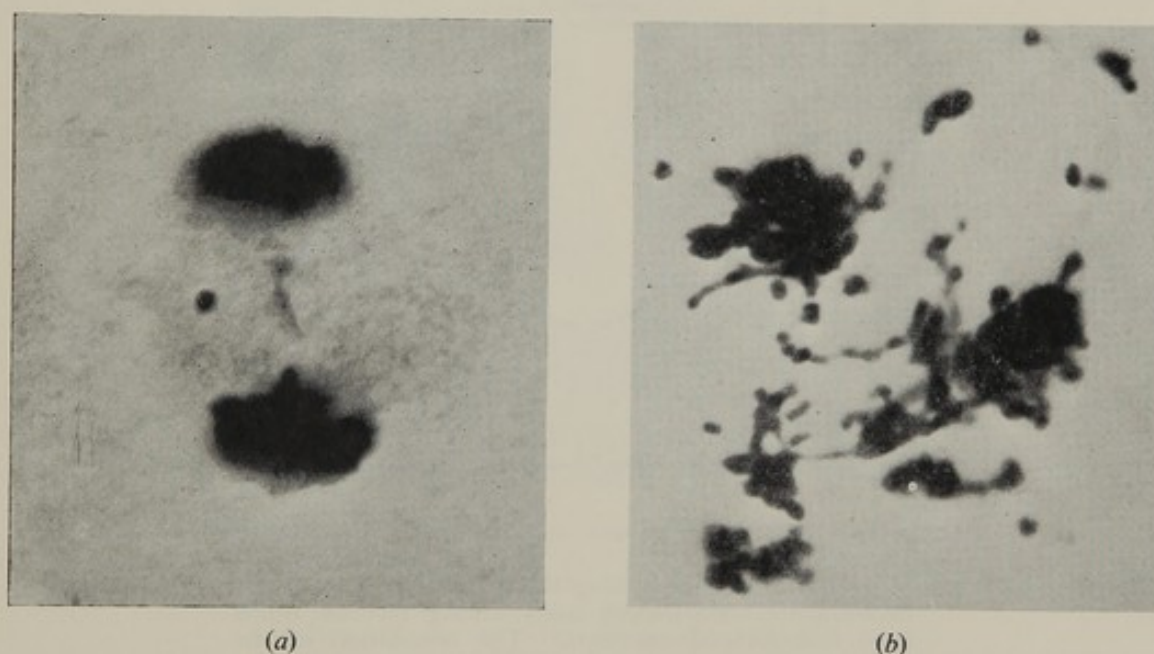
Two dividing cells of carcinoma of the cervix uteri showing chromosome injuries 24 hours after irradiation with x-rays: (a) dose 25 roentgens, (b) dose 2,500 roentgens. The amount of chromosome-fragmentation is related to the dose. $\times 2000$.
